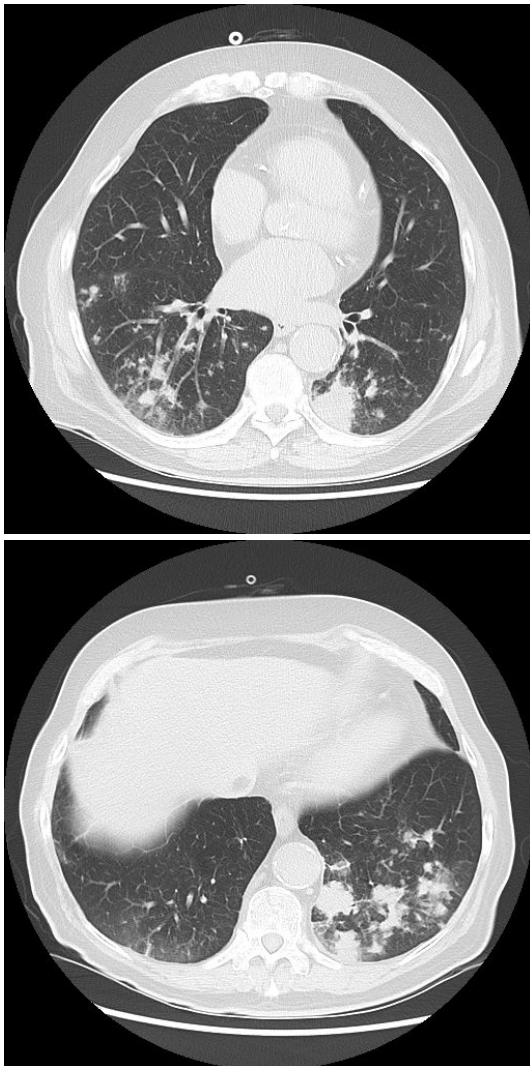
Pulmonary nocardiosis. Thoracic CT: multiple bilateral nodular infiltrates.
